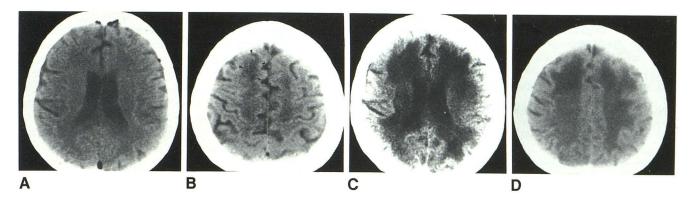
Case 2. Unenhanced CT scans at 1 month (A and B) and $1\frac{1}{2}$ months (C and D) after admission. A, At level of lateral ventricles. Dilatation of cortical sulci. (Intracranial air was secondary to recent brain biopsy.) B, At level
